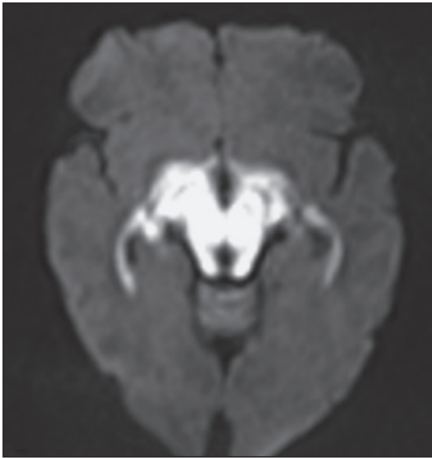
Axial diffusion-weighted imaging (DWI) magnetic resonance imaging (MRI) shows restricted diffusion in midbrain
